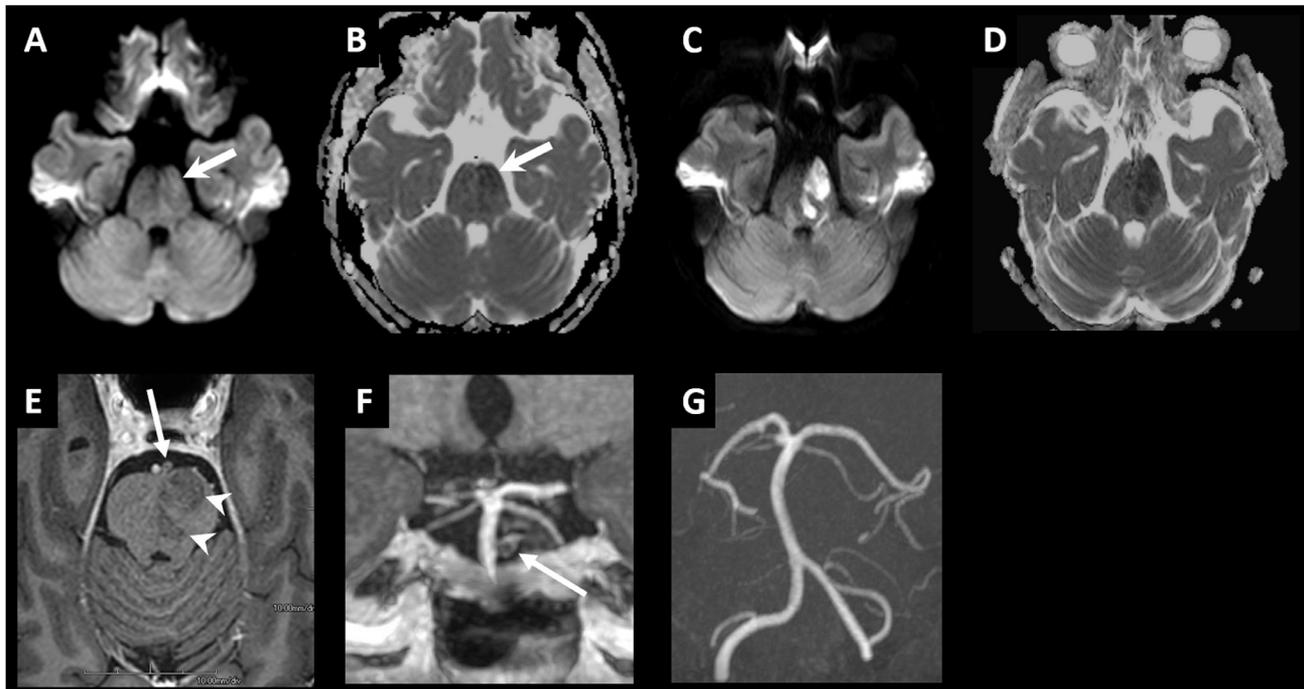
Diffusion-weighted imaging (DWI) (A) obtained at 2.5 hours after the onset of neurological symptoms revealed a faintly hyperintense lesion in the left side of the pons with corresponding low diffusivity on apparent diffusion coefficient (ADC) map (B) (arrow). Follow-up DWI (C) and ADC map (D) obtained 6 days later revealed clearly defined infarction in the left side of the pons with decreased diffusivity. Axial (E) and reformatted (F) coronal images from contrast-enhanced magnetization prepared rapid gradient echo imaging revealed the presence of a nonenhanced ovoid lesion (arrow) close to the enhanced basilar artery. Pontine infarction was observed as an area of decreased signal intensity on the same side as the ovoid lesion (arrowheads). The ovoid lesion was not observed using magnetic resonance angiography (G). Note the proximity of the ovoid lesion and pontine infarction and their position on the left side.
